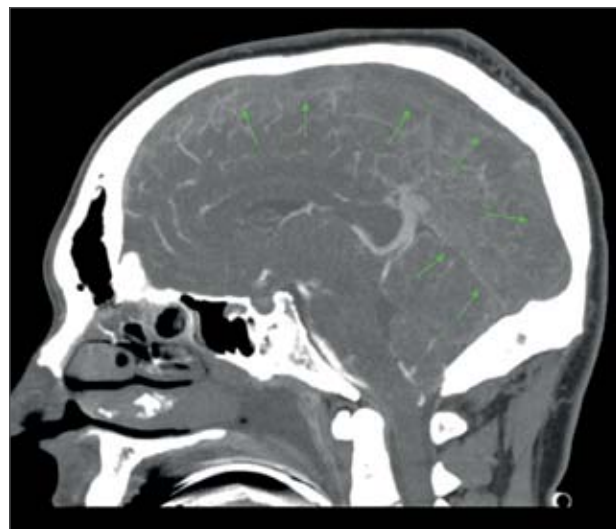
Computed tomography angiography with no contrast enhancement of the straight sinus and superior sagittal sinus (green arrows).
